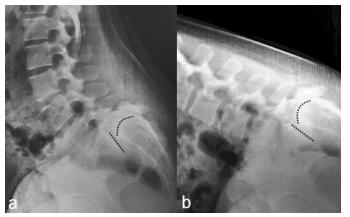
Dynamic lateral lumbar radiographs obtained in partial flexion (a) and full flexion (b). The curved dotted line represents the rounded-off superior surface of the sacral base (the S1 superior vertebral body surface) and the straight dotted line represents the inferior L6 vertebral body endplate surface. The L6 segment translates approximately 5 mm anteriorly and inferiorly in relation to S1 indicative of instability.
